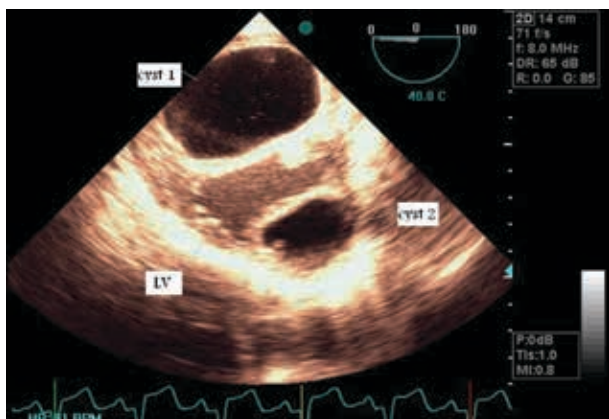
Transesophageal Echocardiography Showing Cardiac Cysts
